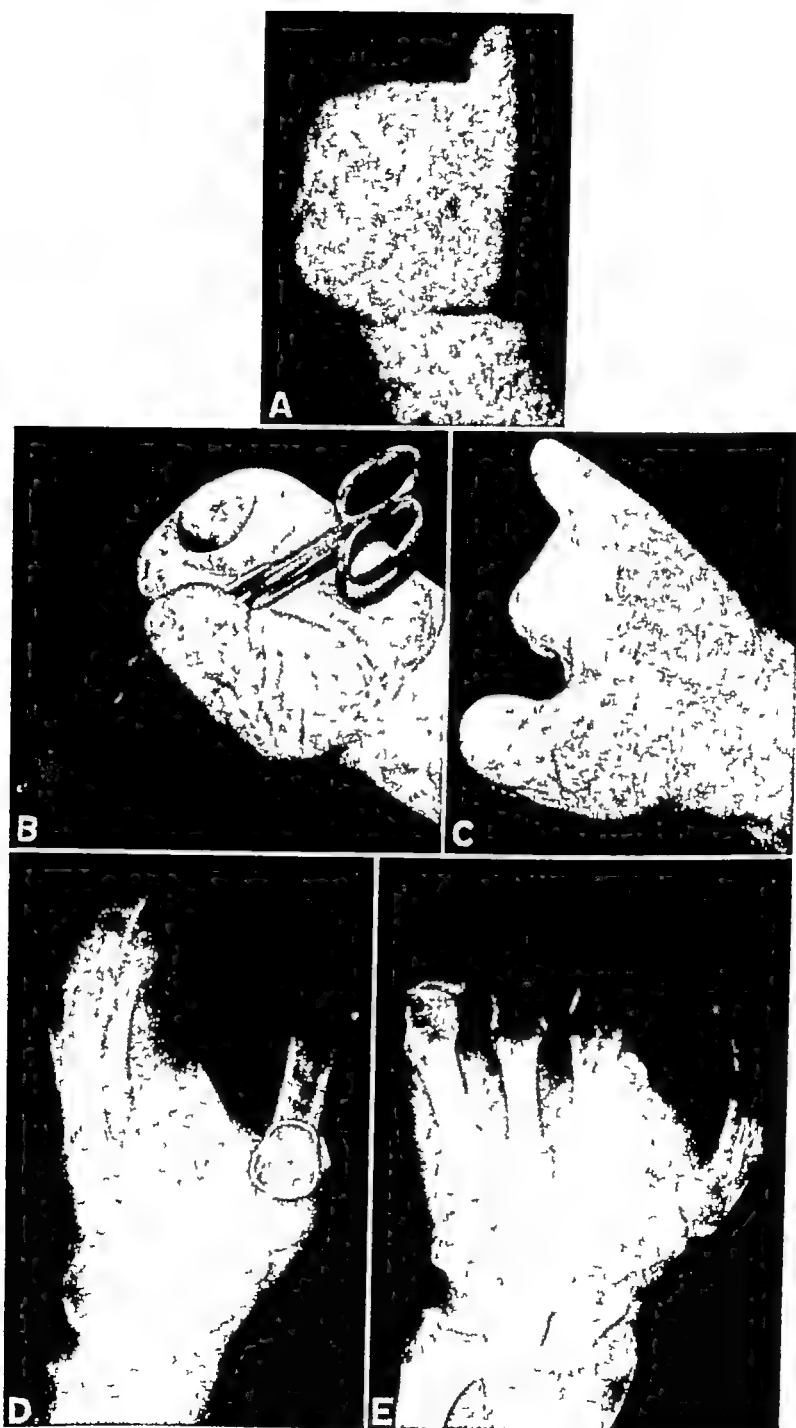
Formation of cleft in digitless hand by shifting index metacarpal with attached skin to thumb position *A*, preoperative, *B* and *C*, function obtained postoperatively, *D* and *E*, postoperative x-rays
